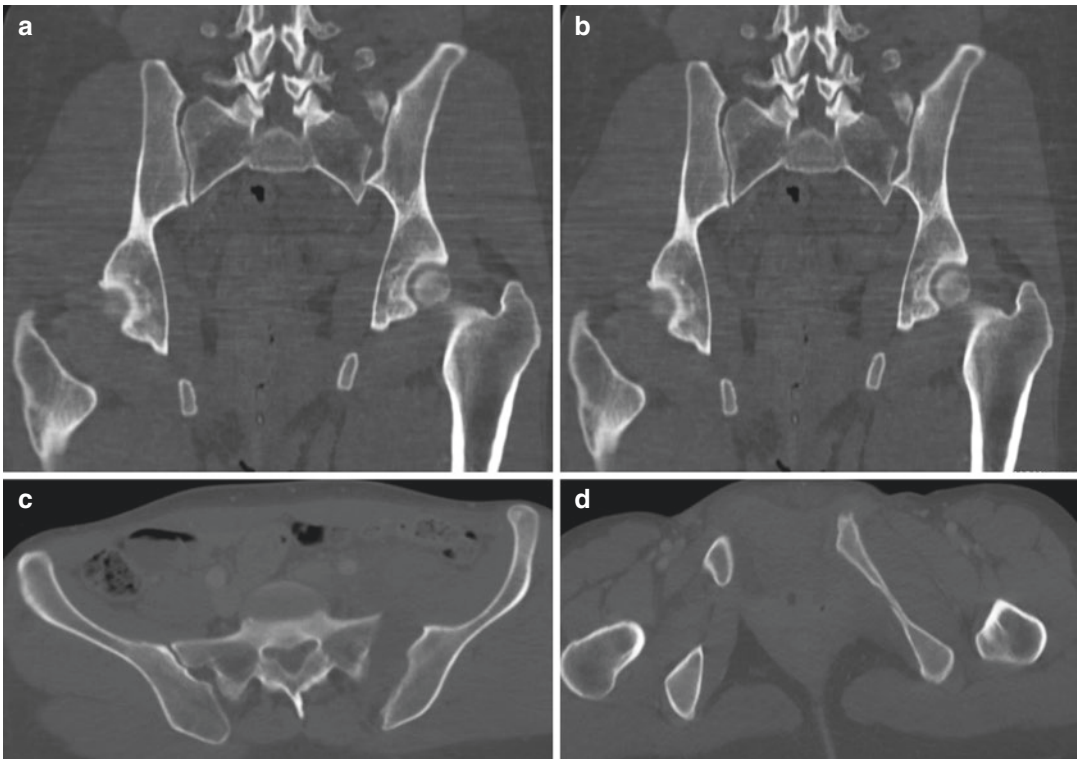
(a–d) “Vertical shear” (VS) fracture. (a, b) CT scan MPR coronal view (a, b) and CT axial view (c, d) show the involvement of posterior pelvic elements. The vertical vector forces result in the destruction of the pelvic
